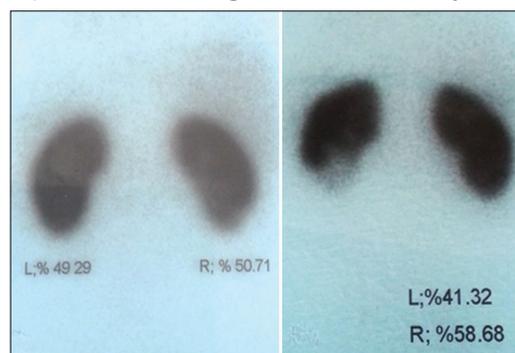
Images from the same patient (a) preoperative normal scintigraphic image and (b) postoperative scar image in the lower pole of the left kidney
